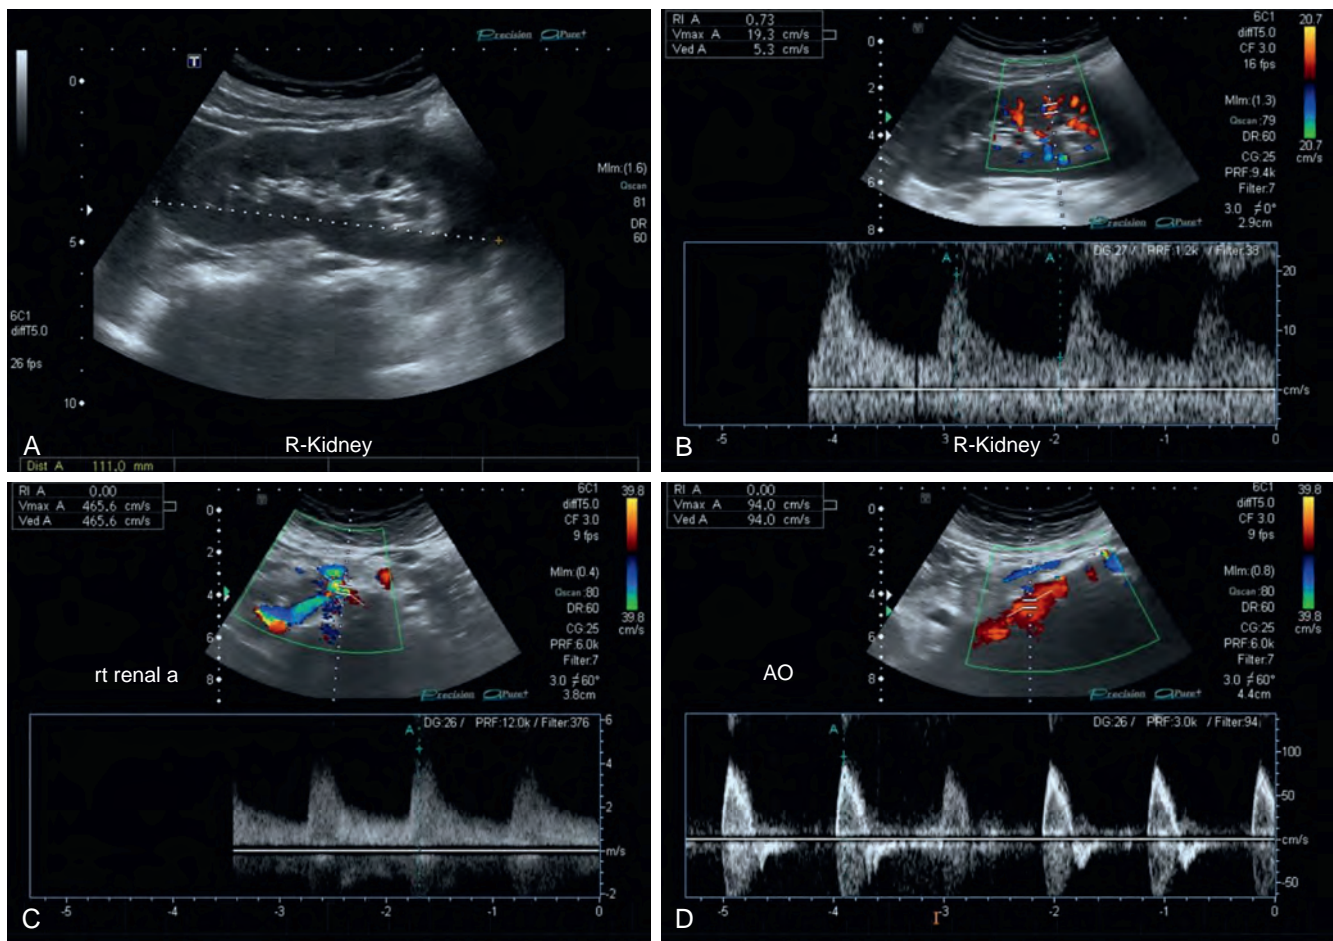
Renal ultrasonography and Doppler interrogation in a 65-year-old patient with poorly controlled hypertension. The resistive index within the renal parenchyma was 0.73. The right renal arterial peak systolic velocity reached up to 465.6 cm/sec at the ostium compared with peak systolic velocity of 94 cm/sec in the aorta (AO), suggesting severe (>50%) right renal arterial stenosis. A, Renal ultrasonography in B mode. B, Color Doppler of the renal parenchyma. C, Measurement of peak systolic velocity in right renal artery (rt renal a). D, Measurement of peak systolic velocity in the aorta. R, right.
